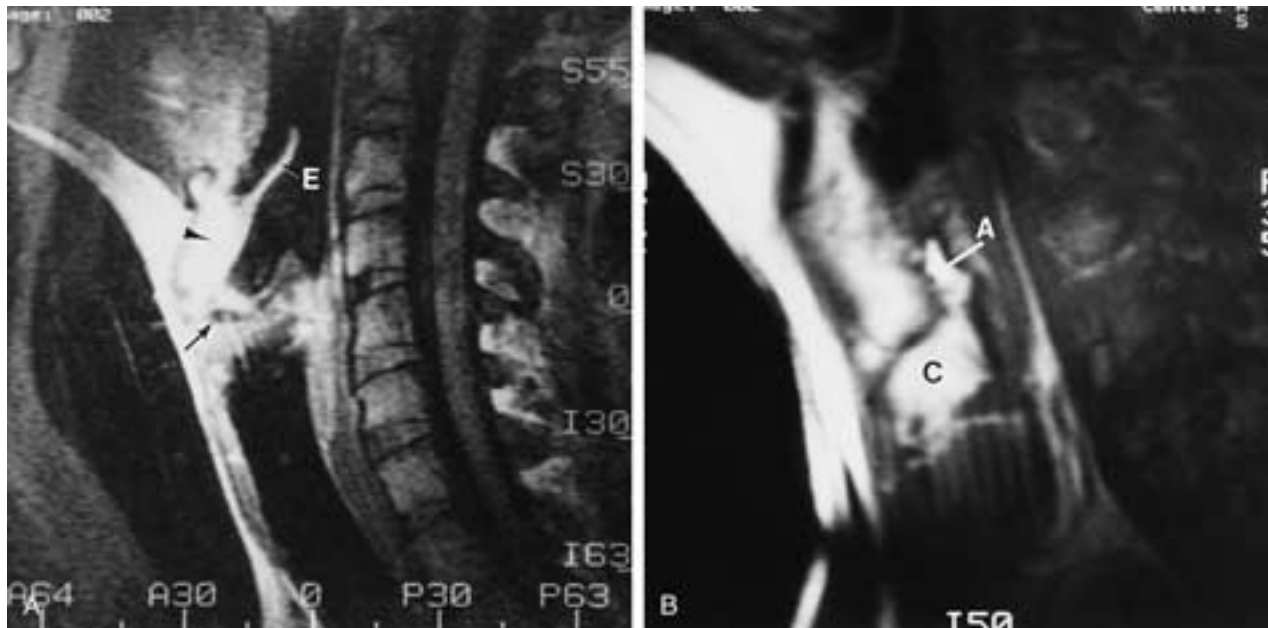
A, MR image, 1.5 Tesla, T1-weighted sagittal image, just off the midline, shows the true cord and false cord separated by the dark air-filled ventricle (arrow). Arrowhead, Preepiglottic fat; E, epiglottis. B, More lateral scan shows the cricoid (C) and arytenoid (A).
